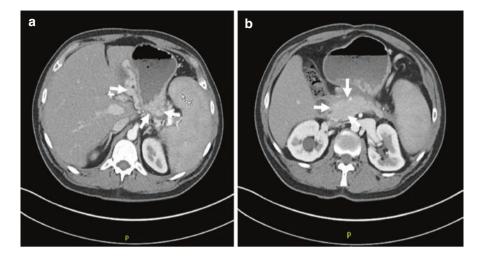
Abdominal computed tomography (CT) of a patient with recurrent life threatening Pancreatitis, splenic vein thrombosis, and brittle diabetes. (a) Massive gastric variceal and pancreatic collaterals (*arrows*). (b) Large pancreatic tumor with failed attempts of surgical resection at a local hospital. The patient underwent successful near total pancreatectomy combined with splenectomy and complete gastric devascularization
